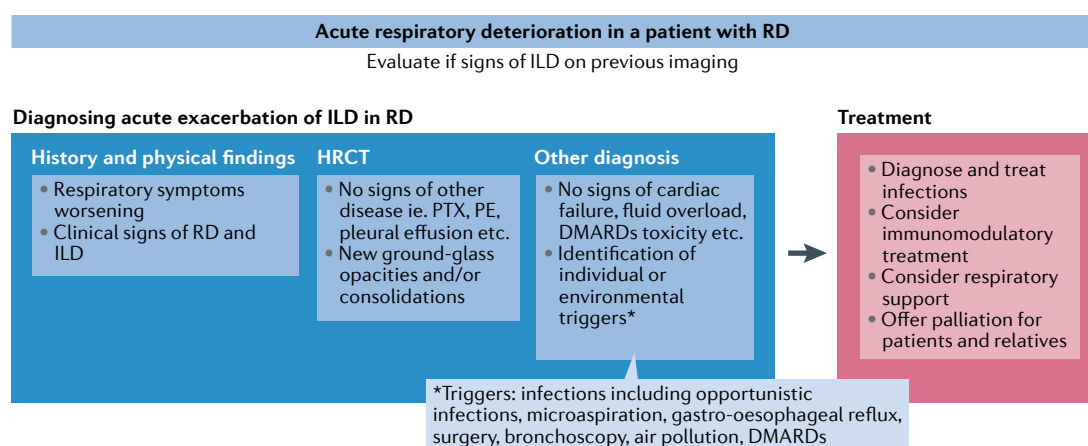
Diagnosis and treatment of acute exacerbation of interstitial lung disease in rheumatic disease. Acute exacerbation of interstitial lung disease (ILD) in patients with rheumatic disease (RD) is a clinical diagnosis based on worsening of respiratory symptoms in a patient with known or newly diagnosed RD, worsening or new radiological features, and the exclusion of other diseases. HRCT, high-resolution CT; PE, pulmonary embolism; PTX, pneumothorax.
